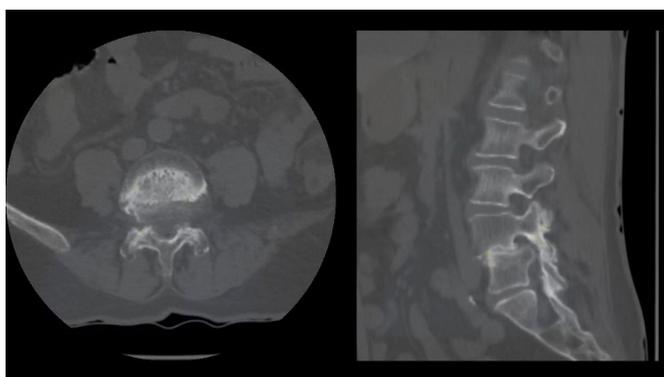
Preoperative CT. Foraminal stenosis caused by L5 superior endplate and osteophyte.
